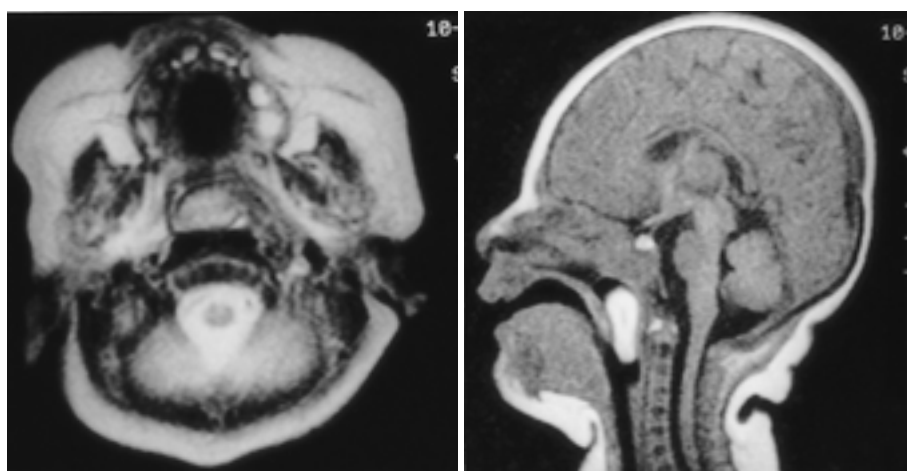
Post contrast CT scan (A) shows a low density polyp (arrow) with pedicle (arrowheads) arising from left lateral wall of the nasopharynx. This polyp is high signal intensity on T1WI (B) and T2WI (C). It is not enhanced after infusion of the contrast media except for pedicle (not shown). Obstruction of the naso- and oro-pharyngeal air-way and no intracranial communication are well demonstrated on sagittal T1WI (D). Microphotograph shows that a polyp have a surface of mature keratinised stratified squamous epithelium with hair follicles and sebaceous glands ($\times 40$) (E). Adipose tissue and fibrous septa are found in the central portion of a polyp ($\times 5$) (F).
